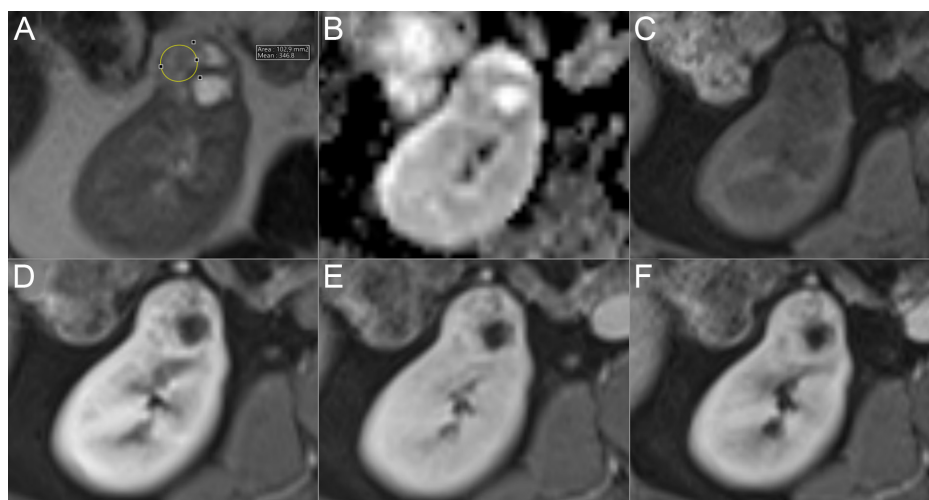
Clear cell renal cell carcinoma in the right kidney of a 63-year-old man. (A) Axial T2-weighted magnetic resonance (MR) image shows the renal mass with high signal intensity compared with renal parenchyma (T2SIR=109.3). A region of interest has been drawn in the solid enhancing region without necrosis avoiding vascular structures and cystic components of the tumor and then reported on all sequences. (B) Apparent diffusion coefficient (ADC) maps show slight restriction of diffusion in the renal mass (ADCr=83.6). Axial non-enhanced (C) and contrast-enhanced T1-weighted MR images in corticomedullary (D), nephrogenic (E), and delayed (F) phases show early and intense enhancement of mass in corticomedullary phase followed by washout (ERc: 366.6, ERn: 329.5, ERd: 321.1). ADCr, ADC ratio; ERc, corticomedullary phase enhancement ratio; ERd, delayed phase enhancement ratio; ERn, nephrogenic phase enhancement ratio.
